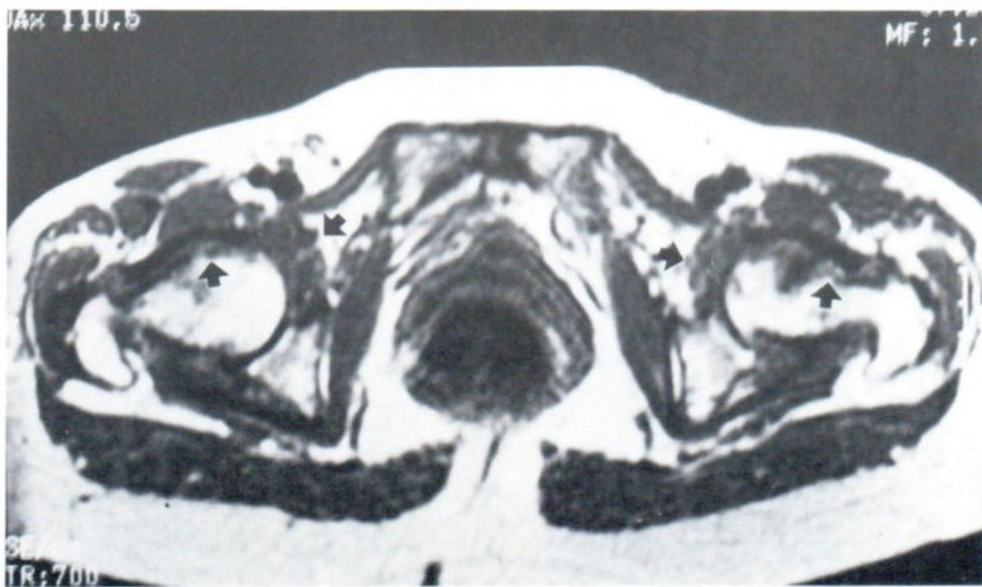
T1-weighted axial MR image reveals low-SI hypertrophied synovium eroding and extending into subchondral bone both of femoral heads / necks and of acetabuli (arrows).
